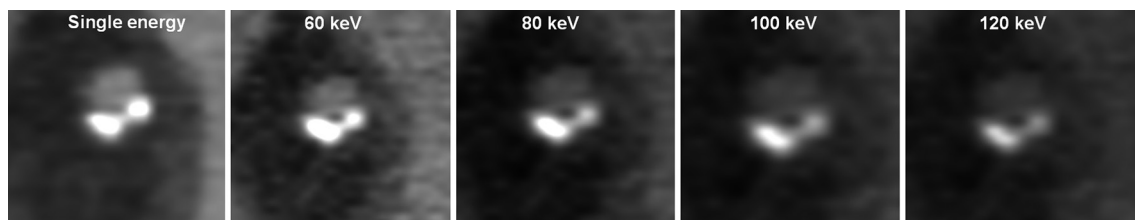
Orthogonal views of a non-significant lesion at the left main coronary artery of the previous patient. A calcified plaque from 3 to 9 o'clock is observed at single energy CT. Dual energy CT at high energy levels demonstrate very mild calcification.
